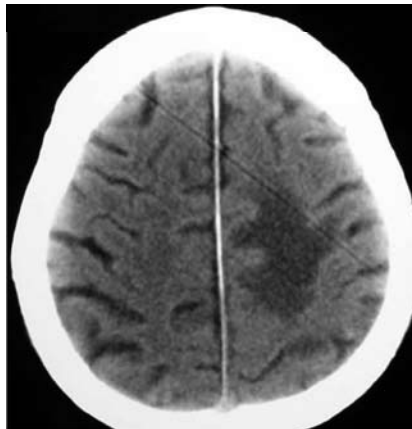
Initial brain CT scan shows a large hypodense region in the white matter of the left parietal lobe.
